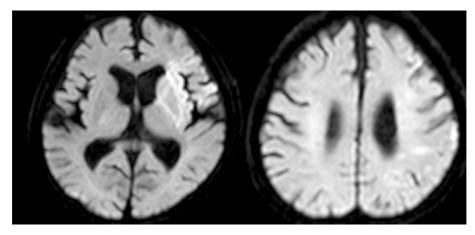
Brain MRI (diffusion-weighted image). Magnetic resonance imaging of the brain showing acute ischemic infarct in the left MCA territory.
